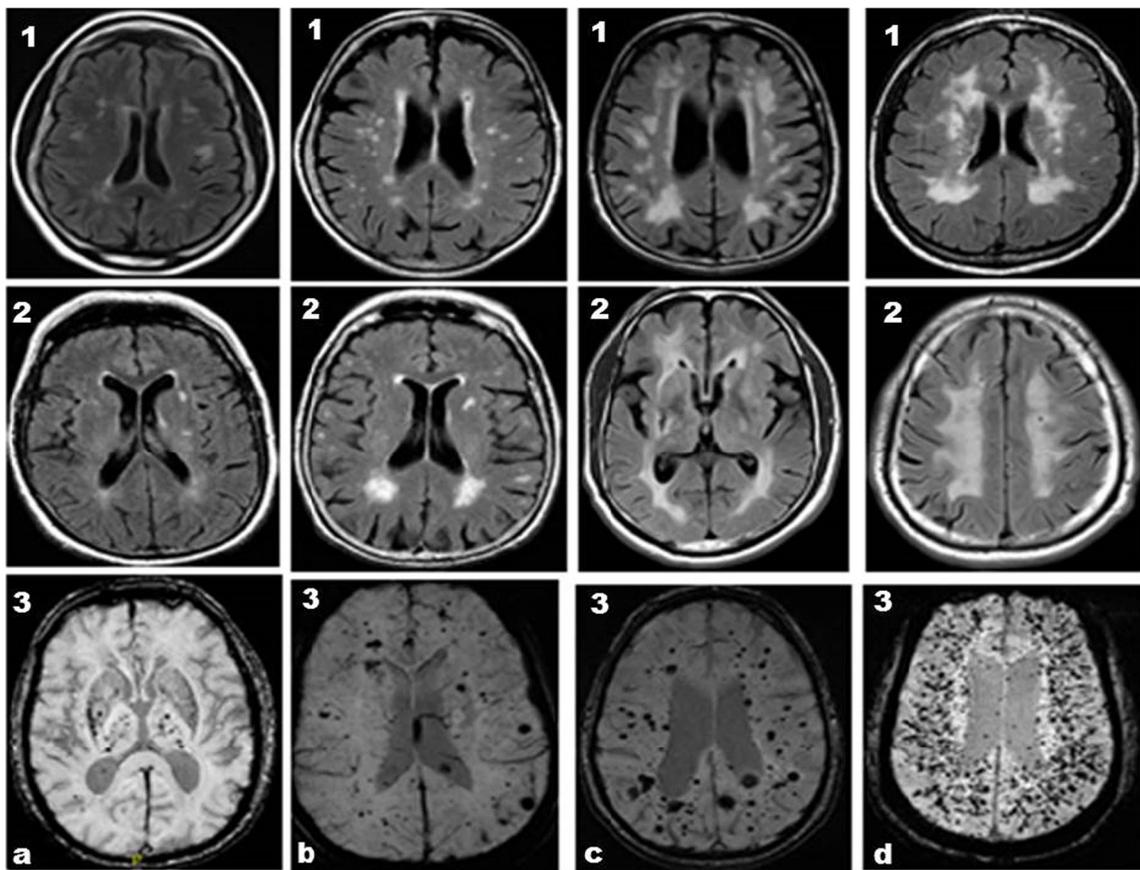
Detection of microbleeds. CMBs are best detected on GRE *Gradient or SWI sequences. FLAIR and T2 may not show the abnormalities (first and second row of images). 2a shows CMBs located only in the basal ganglion. This pattern is most frequently seen in patients with long-standing hypertension. 2b and 2c show increasing CMBs
